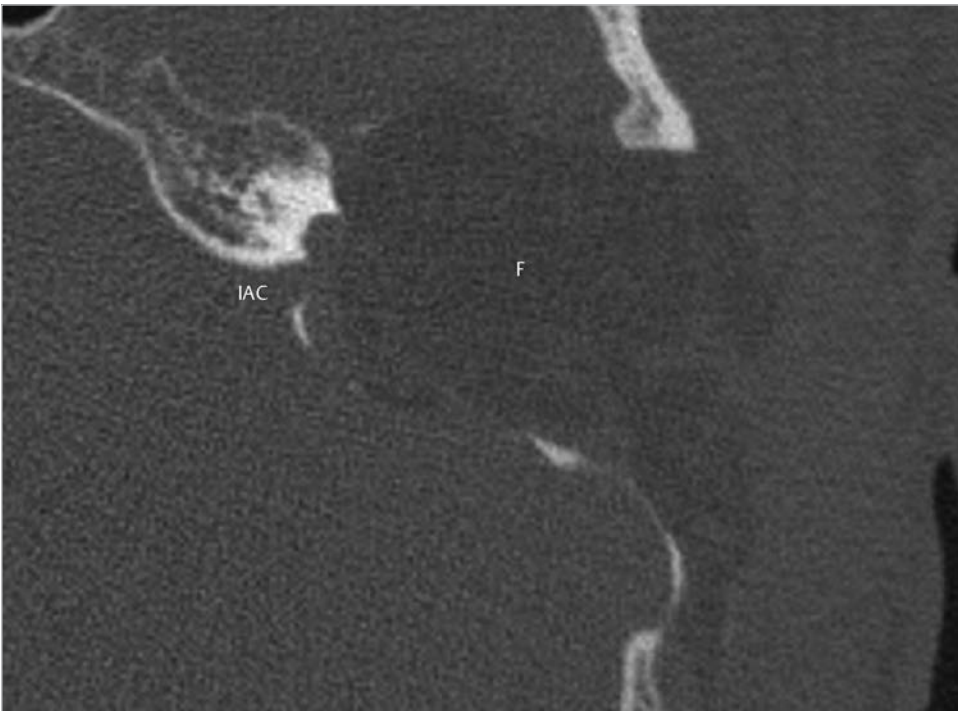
The axial CT at the level of the internal auditory canal demonstrates extensive removal of bone from the petrous apex. F, abdominal fat; IAC, internal auditory canal.
